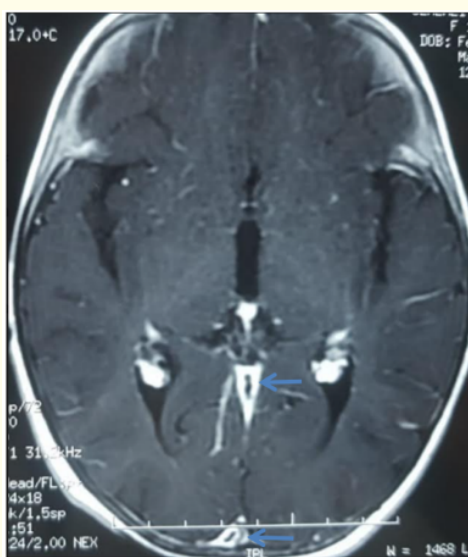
Axial contrast-enhanced T1-weighted brain magnetic resonance imaging (MRI) demonstrating thrombosis of the superior sagittal sinus (Lower arrow) and the straight sinus (Upper arrow).
